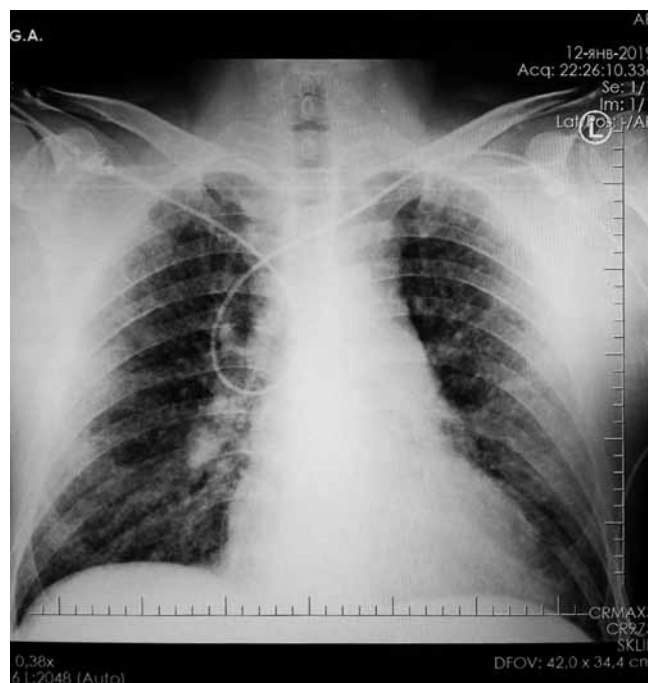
X-ray picture before lung transplantation
